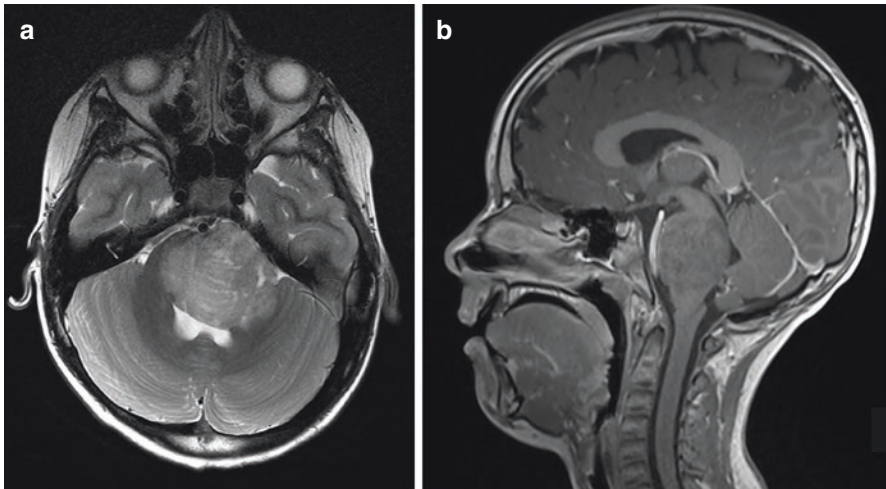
Diffuse Intrinsic Pontine Tumor. (a) Axial T2 weighted MRI demonstrating a T2 hyperintense lesion expanding the pons extending into the cerebellar peduncle and beginning to encase the basilar artery. (b) Sagittal T1 weighted MRI demonstrating a T1 iso to hypointense lesion expanding the pons
